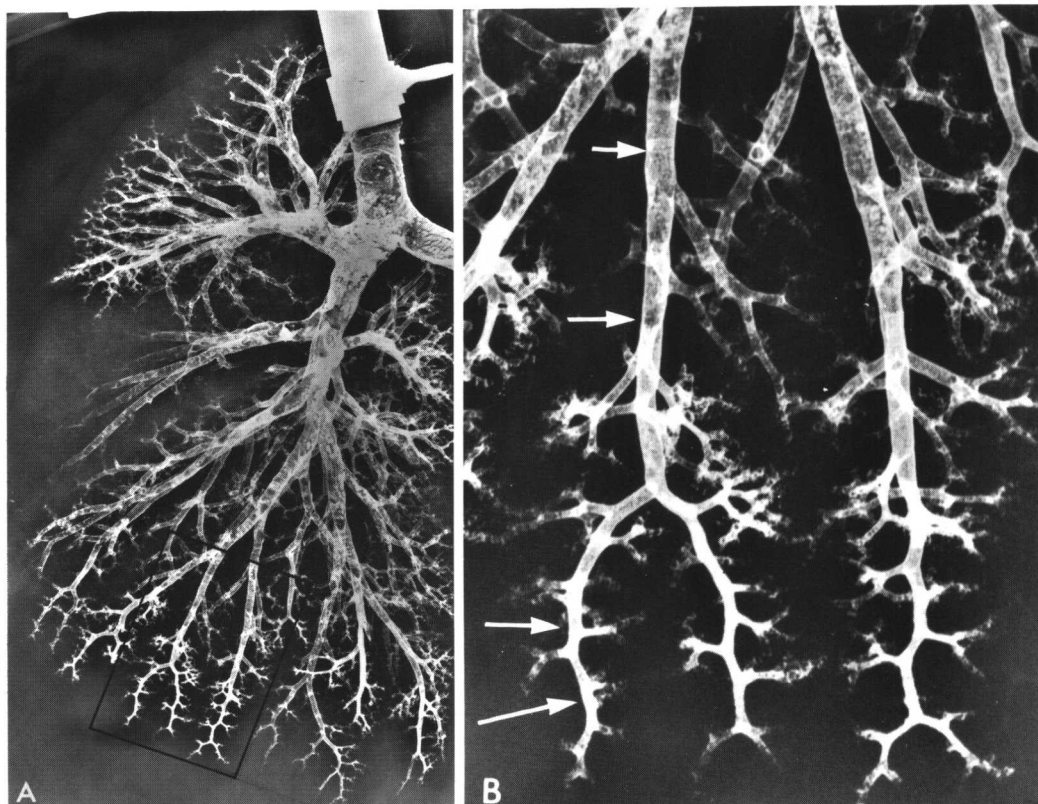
The Pattern of Bronchial and Bronchiolar Branching. *A*, Roentgenogram of an excised right lung following insufflation of particulate lead into the tracheobronchial tree. *B*, Magnified view of the peripheral airways of the lateral basal segment; upper arrows point to the “centimeter pattern” of branching, lower arrows to the “millimeter pattern.” (Roentgenogram through the courtesy of Dr. James Hogg, Department of Pathology, McGill University.)
